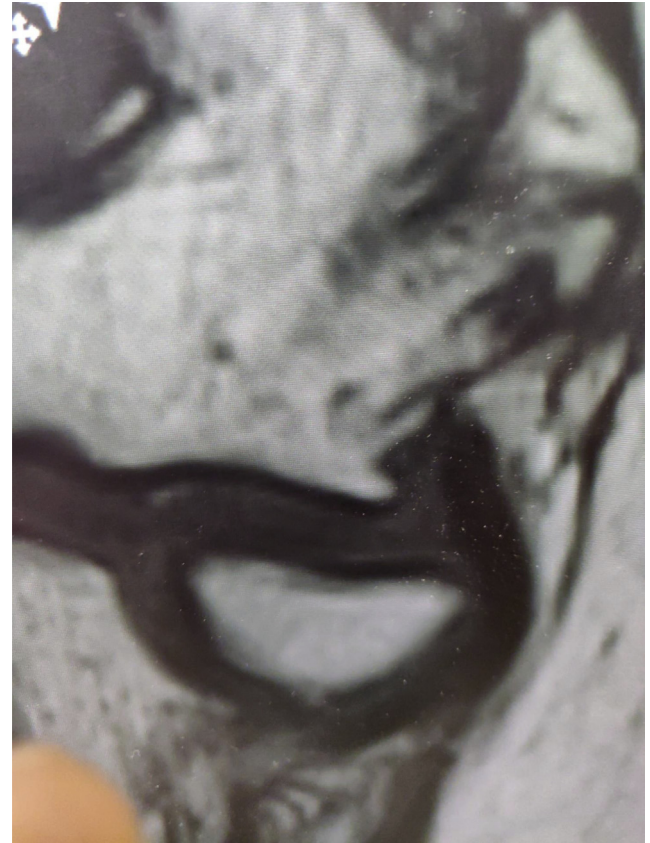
MRI showing resolution of capitellar changes.
